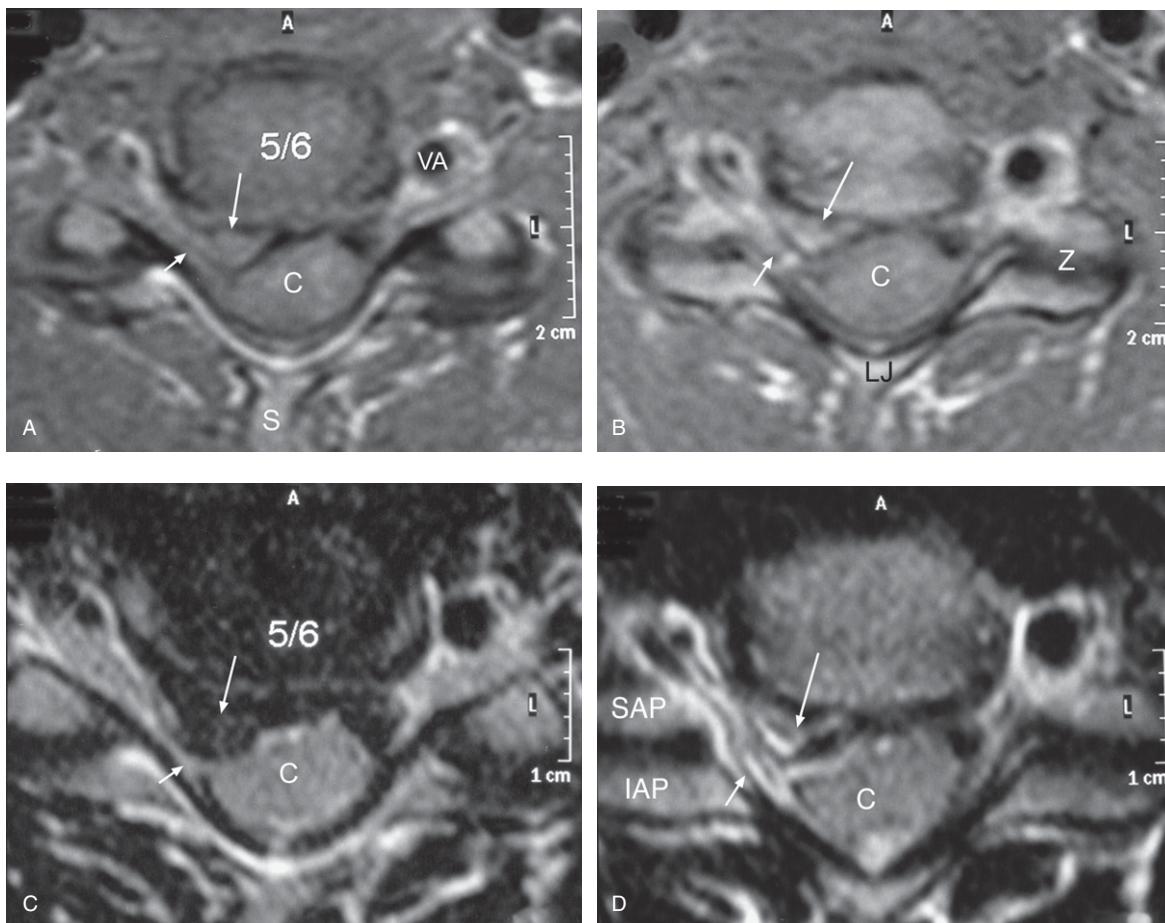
Cervical spine MRI axial T1-weighted images at the C5–6 level (A and B), and T2-weighted images at this level (C and D). Note the prominent right posterolateral disc protrusion (large arrow), extending up to 5 mm posterior to the usual disc margin in the lateral canal and foraminal entrance, posteriorly displacing and rotating the cervical cord (C) and compressing its anterior surface and impinging upon the exiting right C6 root (small arrow). IAP = inferior articular process; L = left side of patient; LJ = lamina junction; S = spinous process; SAP = superior articular process; VA = left vertebral artery within the left transverse foramen that is normal in cross-section while the right artery is hypoplastic; Z = zygapophysial facet joint. (See Fig. 49.12A and B.)
